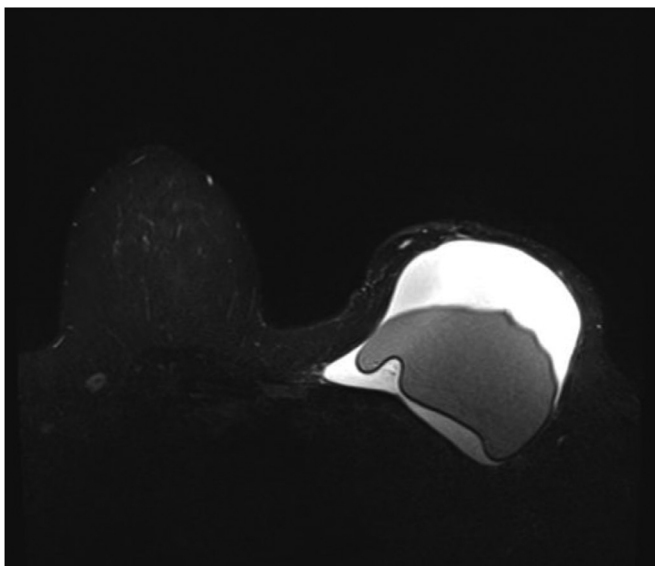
Axial (superior) and sagittal (inferior) T2-weighted MRI images of the left breast, demonstrating a large peri-prosthetic seroma, in a middle-aged patient that originally underwent immediate breast reconstruction with sub-pectoral tissue expander placement and subsequent exchange to a textured, permanent silicone implant. At the time of device removal, approximately 7 years following her index operation, seroma fluid was sent for cytology and confirmed BIA-ALCL.
